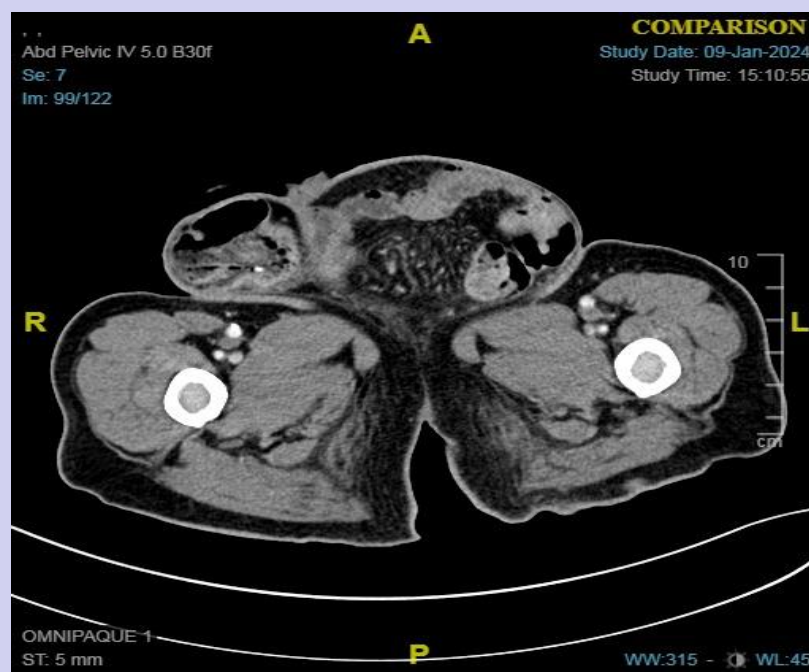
Computed Tomography (CT) scan that revealed bilateral large inguino-scrotal hernias with small bowel content and omentum
